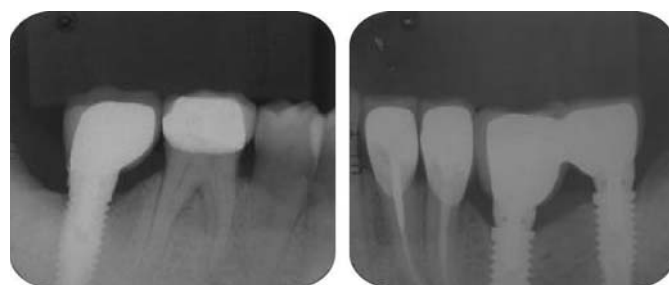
Periapical radiographs of research subjects.
